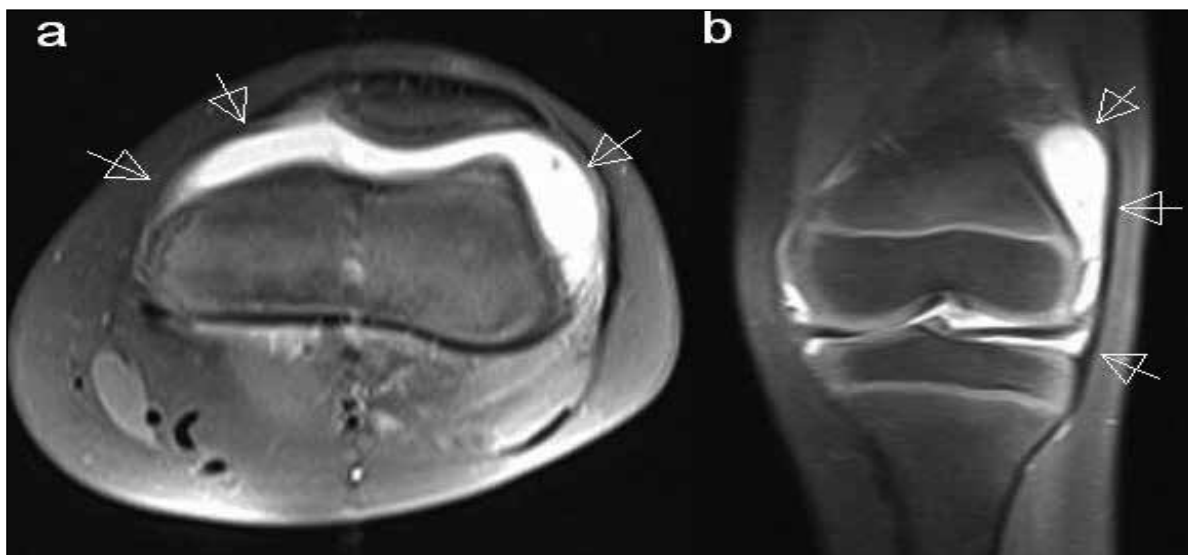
Axial (a) and coronal (b) plane fat-saturated T2-weighted magnetic resonance images of the left knee showed a large amount of joint effusion (white arrows).
